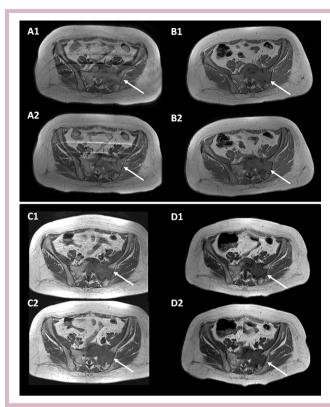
Response to denosumab in a locally advanced GCTB located to the sacrum (case 1). MRI scans (T1 weighted) showed a sacral lesion at baseline (A1–2) and after 3 months of treatment with denosumab (B1–2) with the evidence of a minor reduction in tumour size (stable disease according to RECIST). Disease was stable after 41 months of treatment at the time of ONJ onset. Disease progression was detected 9 months after denosumab interruption (C1–2). A new disease stabilisation was achieved after rechallenging denosumab, as shown by MRI taken 3 months later (D1-2). The white arrows point at the tumour lesion. GCTB, Giant cell tumour of bone; NOJ, osteonecrosis of the jaw.
